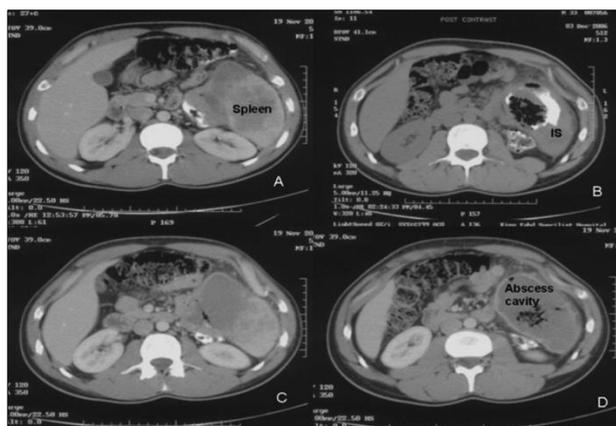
CT- abdomen (plain) showed multiple cavitary lesion in spleen (suggestive of multiple abscess)
